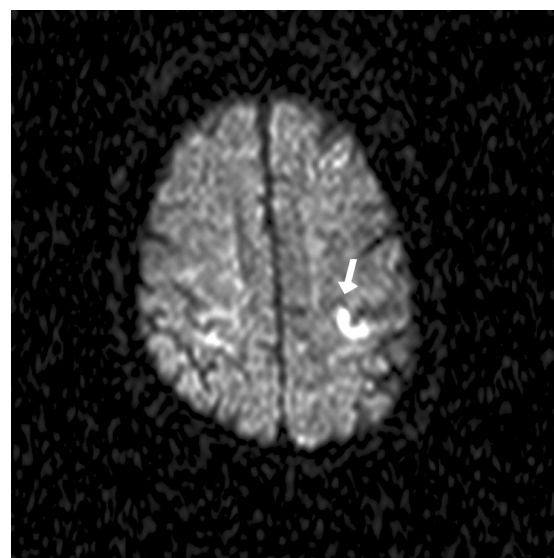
Diffusion weighted MRI sequence showing increased intensity in the hand knob area of the left hemisphere confirming acute ischaemia.
